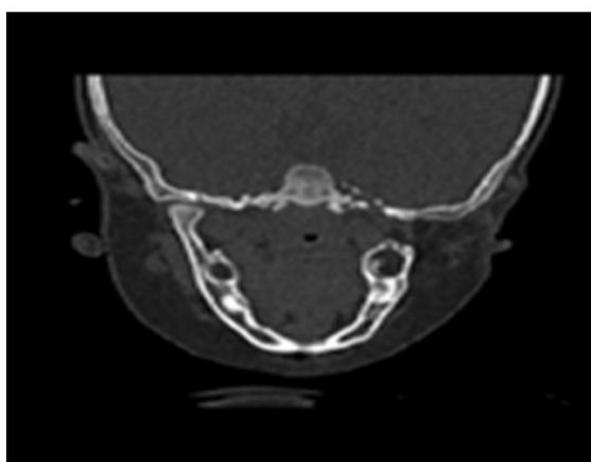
Coronal CT reveals Absence of Mandibular condyle.
